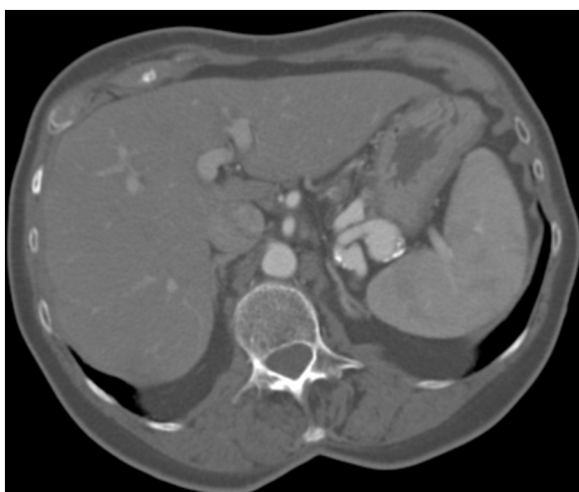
CT-scan of the abdomen showing a 3.1 cm diameter, para-hilar aneurysm of the splenic artery, surgically resected after a failing attempt at trans-catheter coil embolization.
